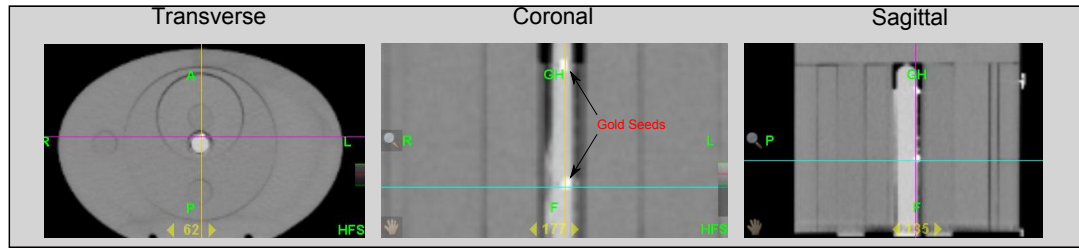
CT scan of solid probe with gold seeds imbedded in surface.
